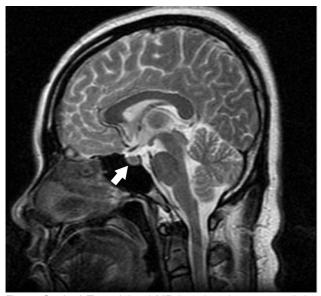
Sagittal T2-weighted MR imaging demonstrated the empty sella (white arrow) in this patient.
